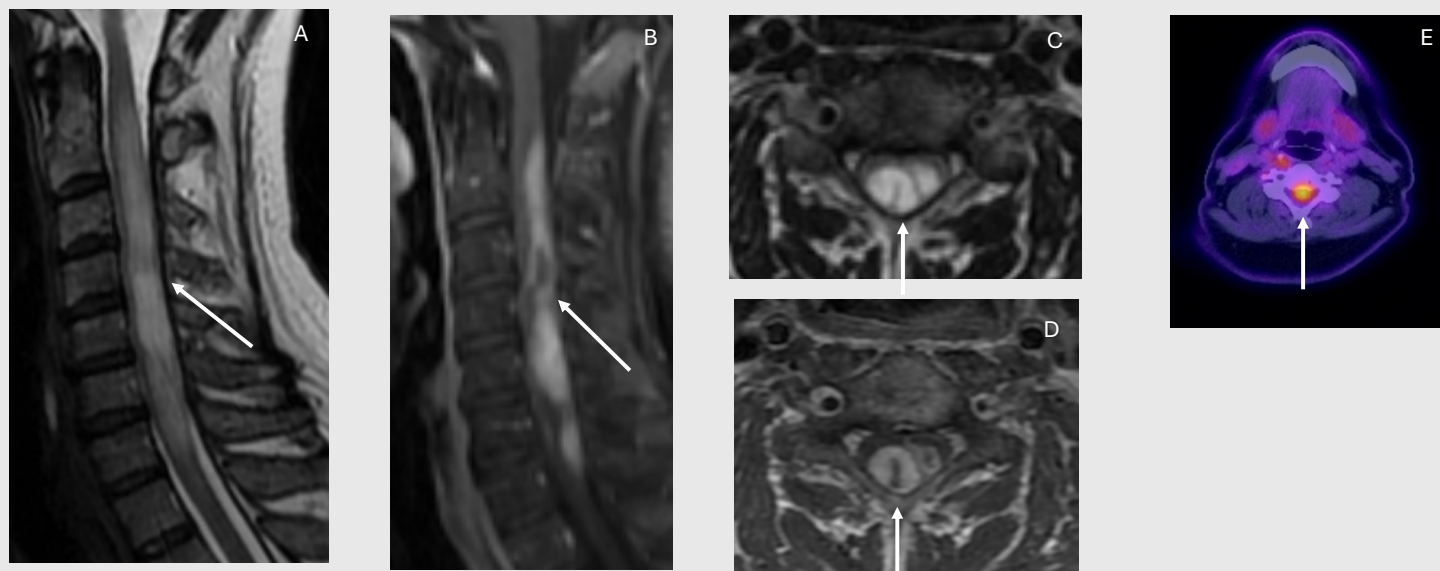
Figure 3A. Sagittal T2WI of the cervical spine demonstrates a long segment mildly expansile T2 hyperintense mass spanning the cervical cord (arrow). Figure 3B. Sagittal post contrast fat sat T1WI demonstrates enhancement within the mass. Figure 3C Axial T2WI demonstrates the expansile hyperintense mass (arrow). Figure 3D. Axial post contrast T1WI demonstrates enhancement of the lesion (arrow). Figure 3E. Axial fused PET/CT demonstrates avidity within the lesion (arrow).
